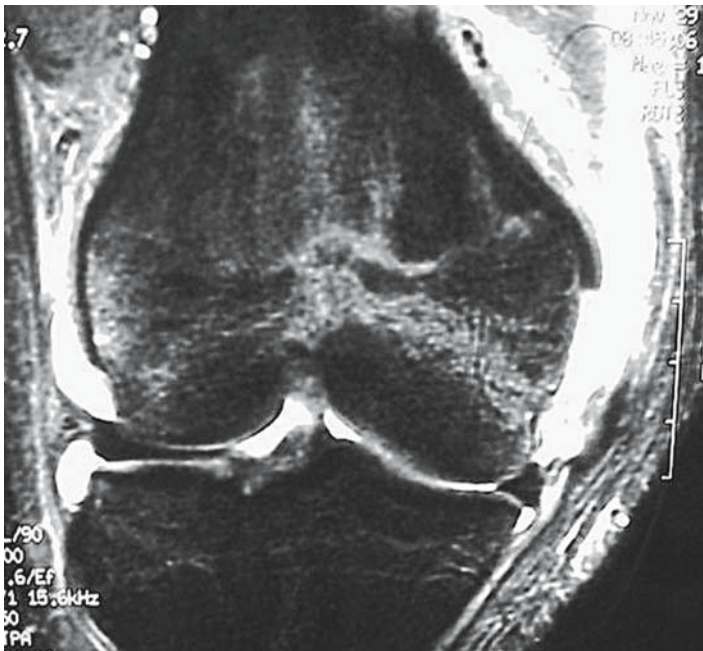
MRI of knee demonstrating medial collateral ligament (MCL) injury.
